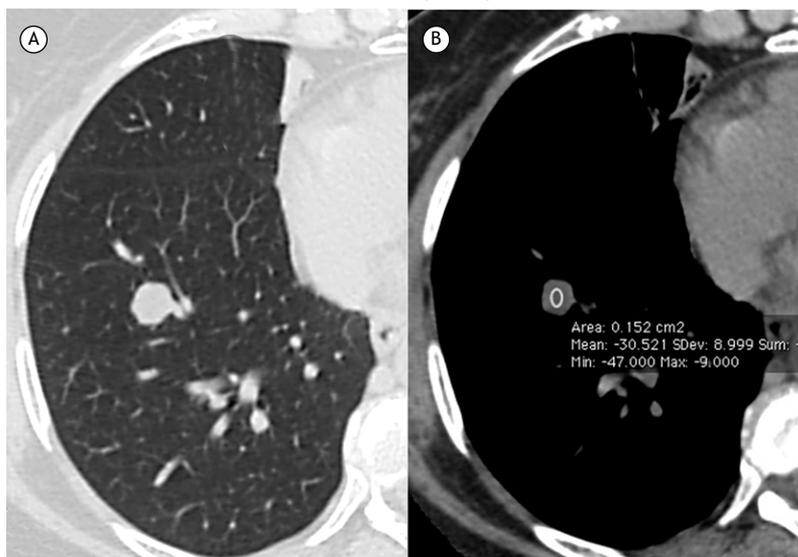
Chest CT in lung (A) and mediastinal (B) windows shows a well-defined nodule, measuring approximately 10 mm in diameter, in the right lower lobe. Note in B that the nodule has fat density (mean density, -30 HU).
